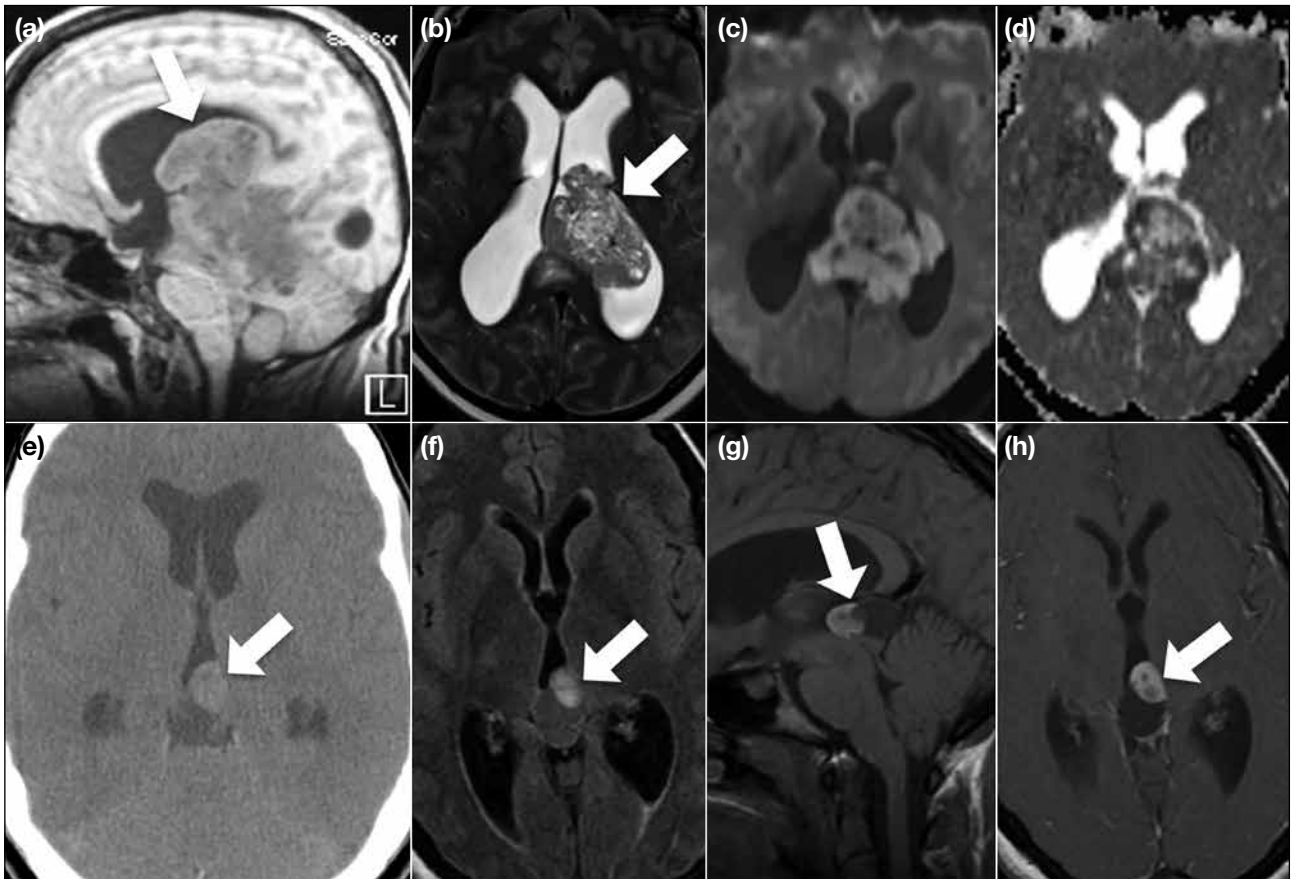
Large pineal parenchymal tumour of intermediate differentiation. Case 1 shows a large lobulated tumour (arrows in [a] and [b]) in the pineal region with extension into the left lateral ventricle and invasion of the adjacent corpus callosum. It is iso- to hypointense on sagittal T1-weighted image (a), with heterogeneous signals on axial T2-weighted image (b). Diffusion-weighted imaging (c) shows water restriction and apparent diffusion coefficient image (d). Case 2 displays a heterogeneously hyperdense tumour (arrows in [e] to [h]) in the pineal region on nonenhanced axial computed tomography image (e), with hypointense and hyperintense parts on the axial T2-weighted fluid-attenuated inversion recovery image (f). There are hypo-, iso-, and hyperintense portions on nonenhanced sagittal T1-weighted image (g) and some enhancement on axial T1-weighted image (h).
